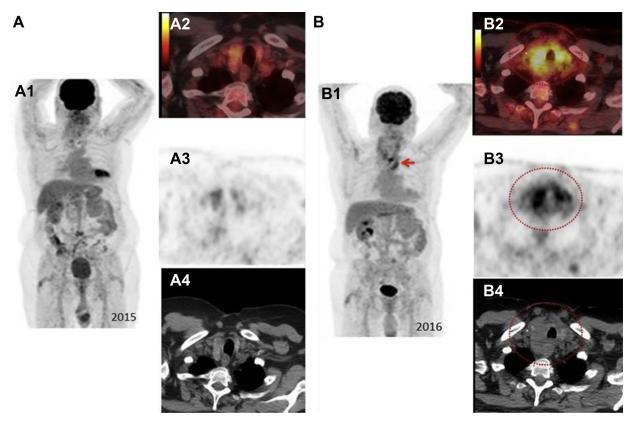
Comparative positron emission tomography computed tomography images demonstrating initial findings (A) and that at subsequent (B) annual surveillance. Maximal intensity projection (MIP), fused axial image, attenuation-corrected PET image and computed tomography images are presented. (A) One year ago, the patient had a normal-sized thyroid with expected low-level fluro deoxyglucose uptake. (B) At one-year surveillance follow-up, the patient developed marked thyroid enlargement with avid fluro deoxyglucose uptake. MIP images also demonstrate linear increased uptake in brachiocephalic vein (arrow).
